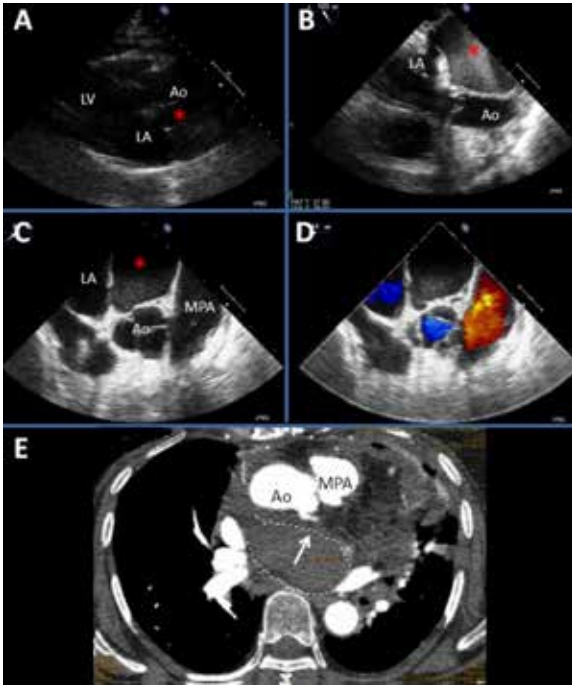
Transthoracic parasternal long axis view (A) showing dissection like image (asterisk) on ascending aorta. Aortic dilatation and dissection were not seen on transesophageal modified long axis view (B). On transesophageal short axis (C) and coloured (D) views, localised fluid accumulation between aorta, left atrium and main pulmonary artery. Multislice computed tomography image (E) demonstrated the collected fluid pinched off the left main coronary artery.
